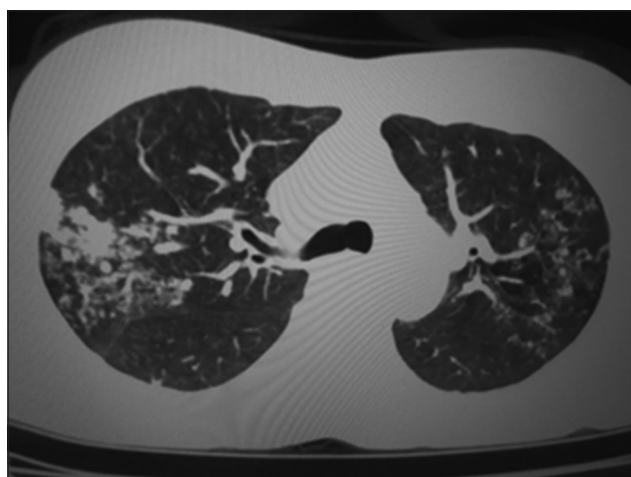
Computed tomography thorax lung window images showing confluent nodules in right lung and centrilobular and tree in bud nodules in left lung
